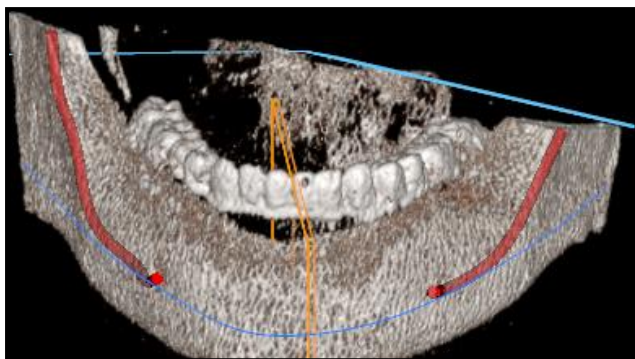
CBCT yields images with isotropic sub millimeter spatial resolution; as a result, its use is perfectly suited for mandibular implant over denture cases
